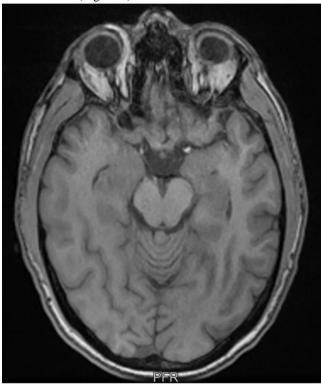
Brain MRI showed mild enhancement of the right trigeminal nerve without other abnormalities.
